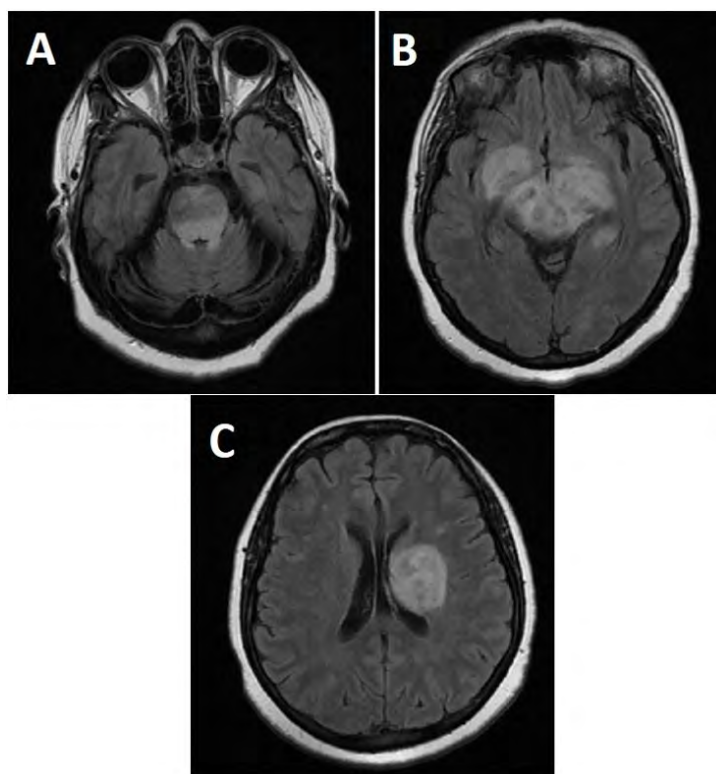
Ressonância magnética de crânio: A, B, C. axial FLAIR.
